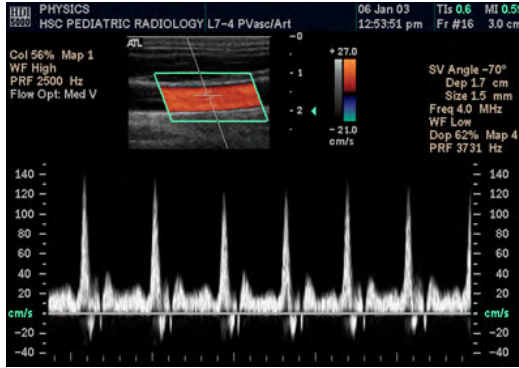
Spectral Doppler scan of a common carotid artery. Adapted from <https://commons.wikimedia.org/wiki/File:SpectralDopplerA.jpg>. By Drickey at en.wikipedia [CC BY-SA 2.5 (<https://creativecommons.org/licenses/by-sa/2.5>)].
